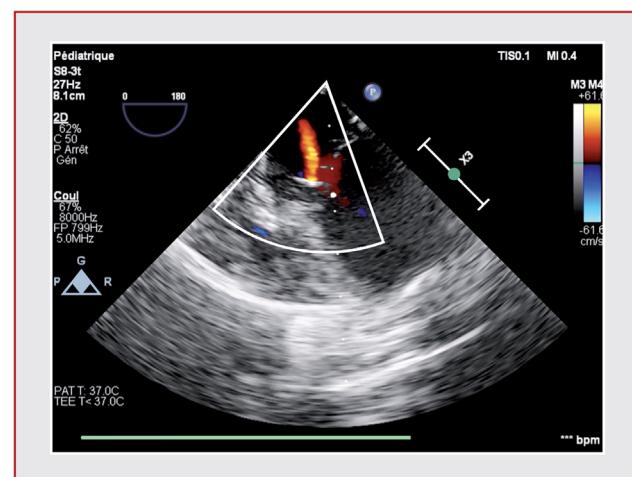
Mild mitral regurgitation following left atrioventricular plasty (cleft) for complete atrioventricular septal defect surgery. Modified midoesophageal four-chamber view with colour-flow Doppler. Residual mitral regurgitation.
